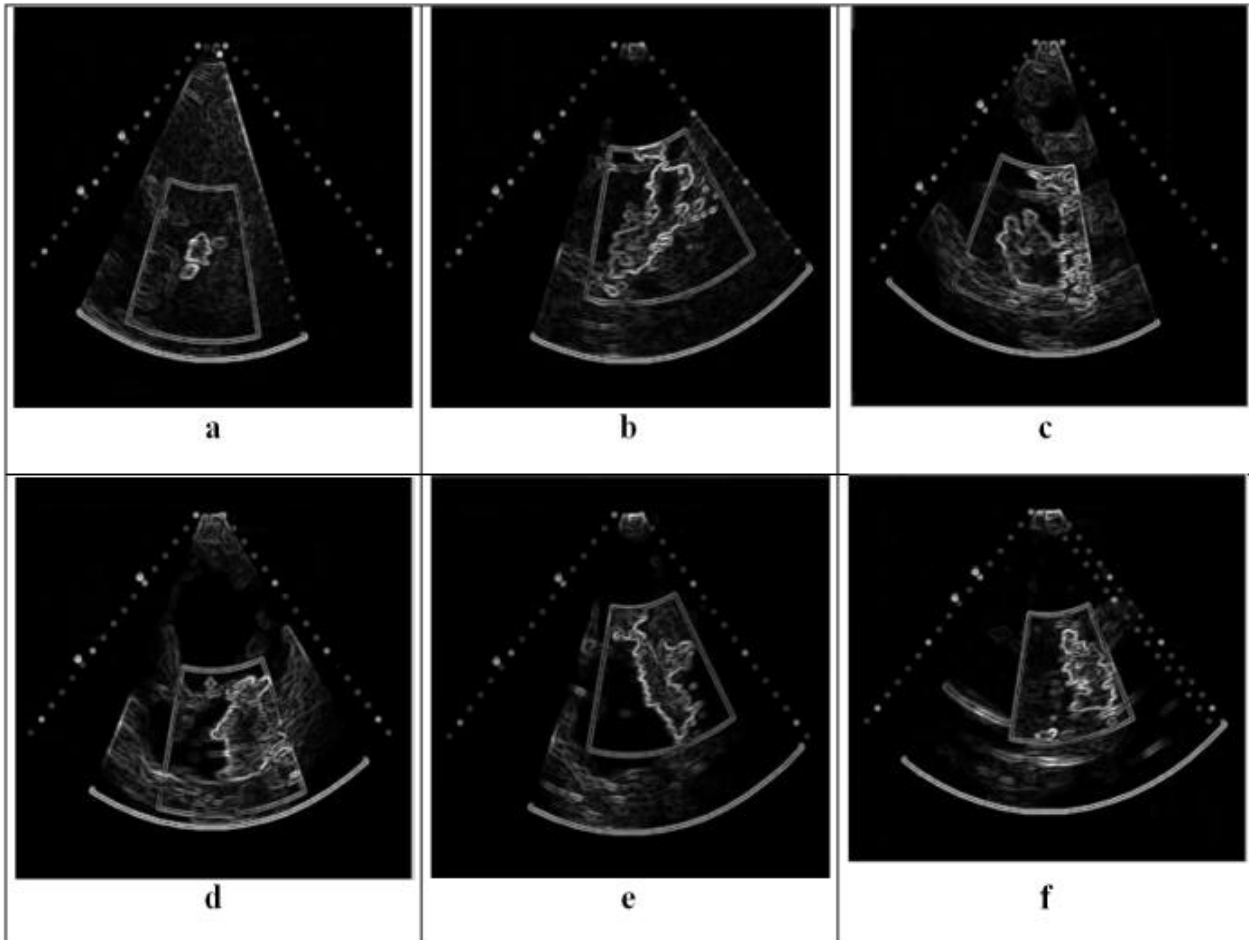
shows the images from patients suffering from mitral regurgitation (MR). These images are taken by the color Doppler echocardiography. Fig. 4.12a is the case of mild MR showing a small mosaic pattern called as MR jet. While other images fig. 4.12b to fig.4.12f having a large mosaic pattern or MR jet shows the severe MR.
